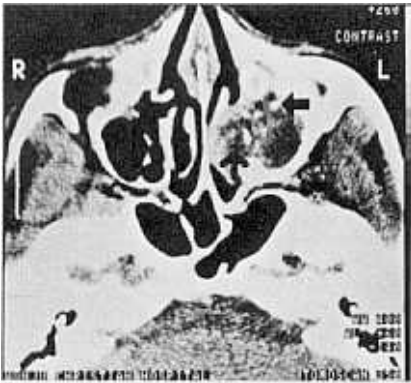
Axial CT scan showing calcification (←), thickening of the sinus wall (↖), and bony destruction (*).
